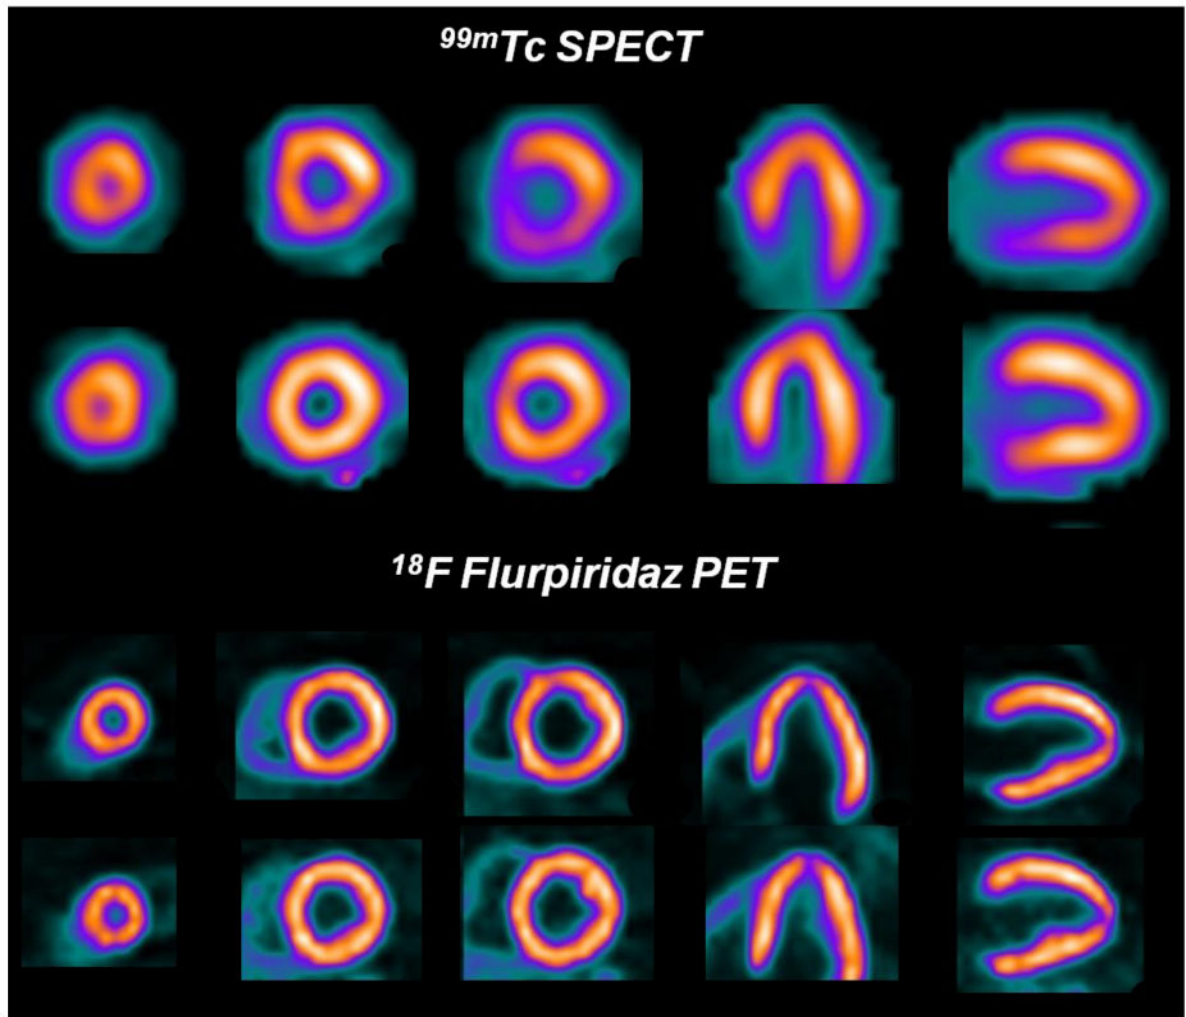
^{99m}Tc SPECT and ^{18}F flurpiridaz PET images in a patient with significant disease in the left circumflex coronary artery. The overall quality of the ^{18}F flurpiridaz PET images (lower rows) was superior to the ^{99m}Tc SPECT images (upper rows). ^{18}F flurpiridaz PET images showed reversible anterolateral wall defects in the distribution of the diseased left circumflex coronary artery, but the ^{99m}Tc SPECT images were normal.
